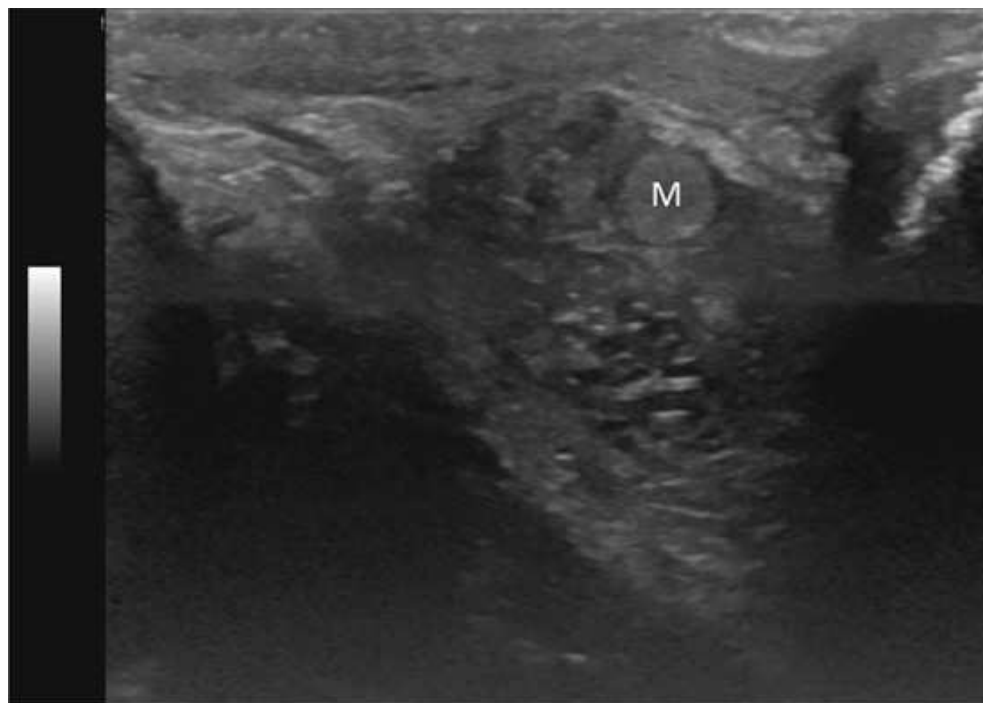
Ultrasound image, sagittal plane. Epididymitis and scrotal mass (*M*). Note enlarged and patchy, mottled echogenicity, as compared with normal epididymis in Fig. 17.23. Courtesy Natalie Cox, RT[R], RDMS[AB][OB], NEA Baptist Memorial Hospital, Jonesboro, AR.
